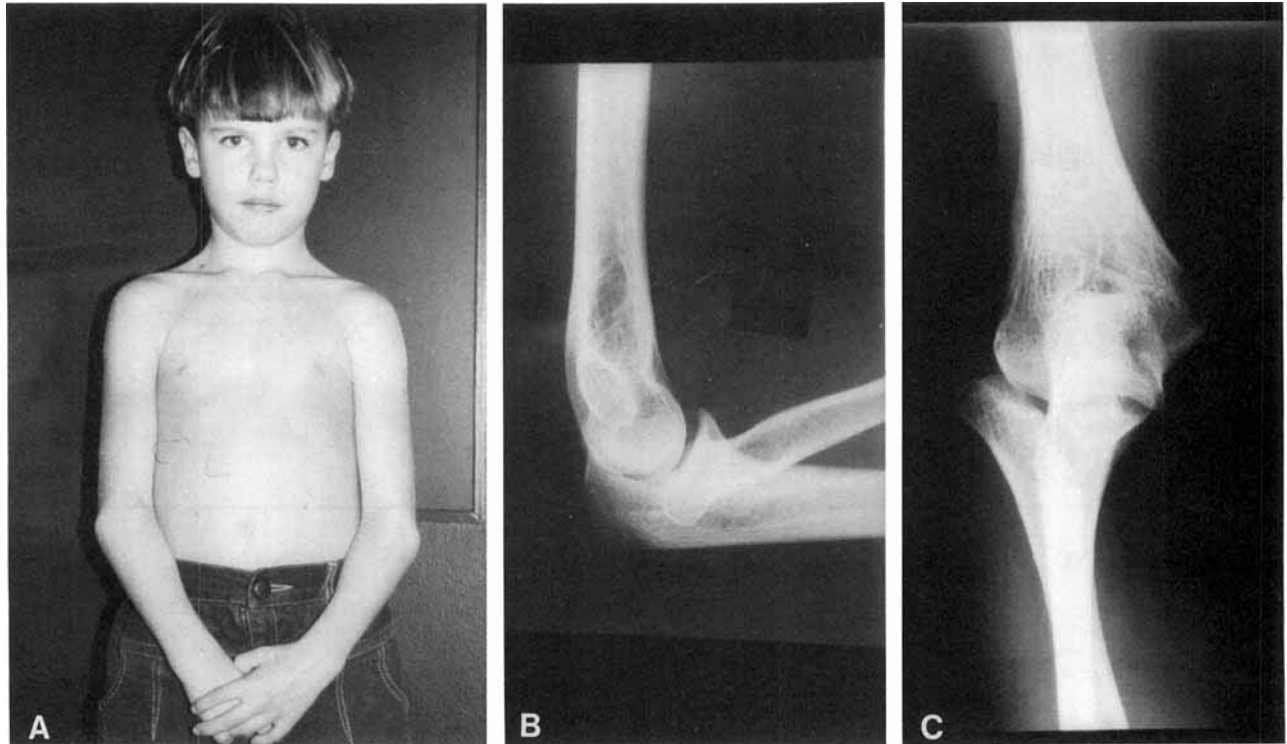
B,C: X-rays of the upper limb of the son (IV-10; A) of the proposita. Note bilateral radial luxations.
